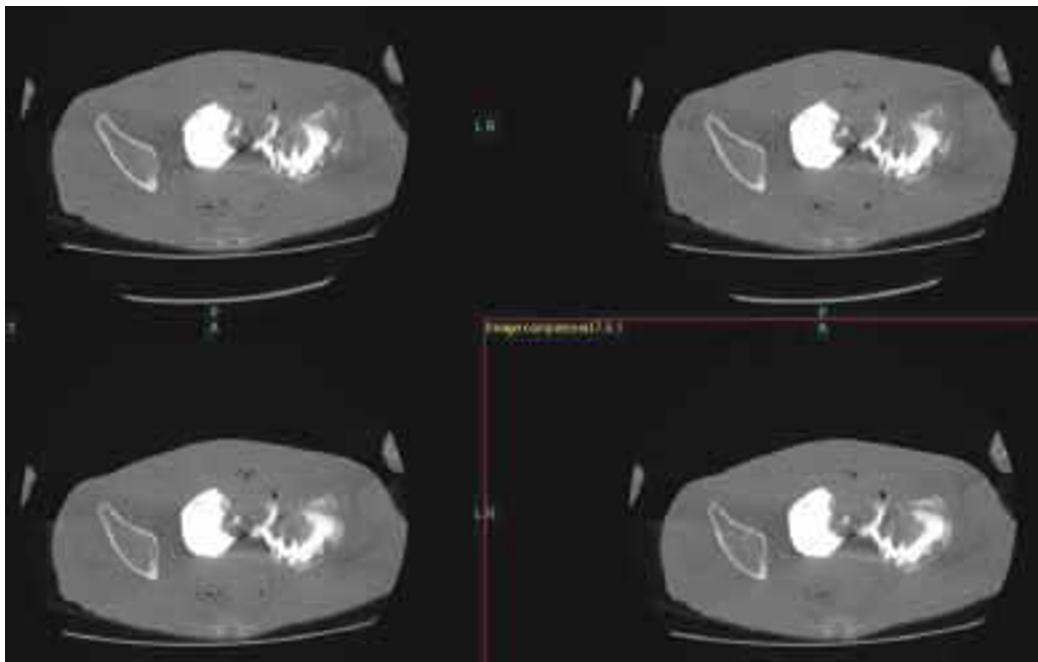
CT cystogram showing contrast extravasation from the left side of the bladder and iliac bone fracture.
